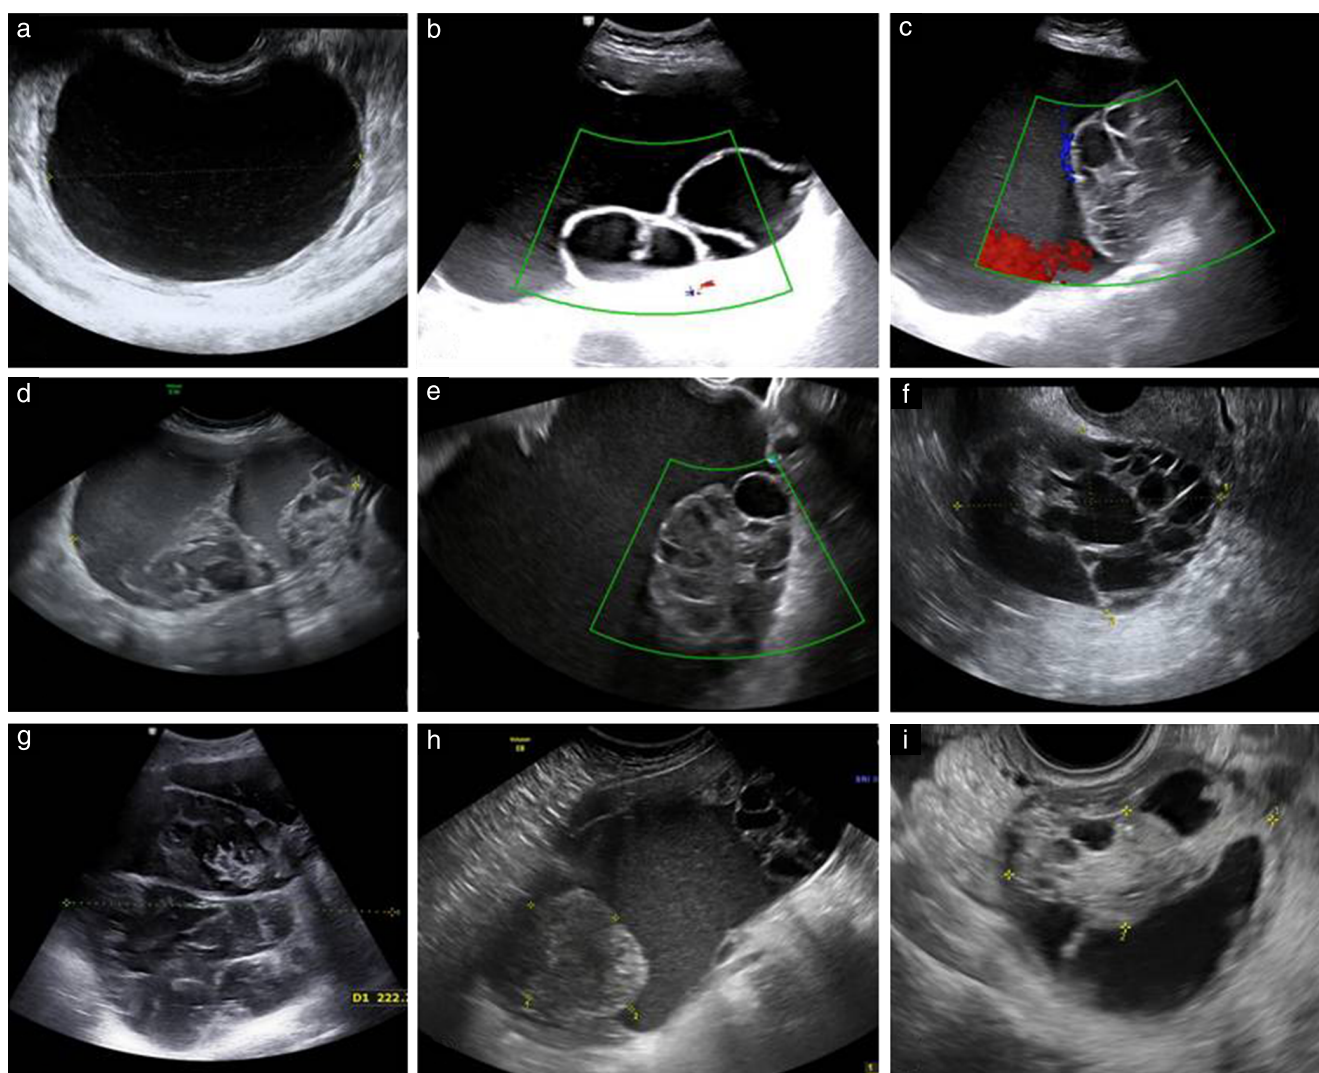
Ultrasound images of gastrointestinal-type borderline ovarian tumors, presenting as unilocular (a), multilocular (b–g) or multilocular-solid (h,i) cysts, the majority being multilocular cysts with > 10 locules (c–g), rather than 2–10 locules (b). Honeycomb nodule can often be visualized (c–e). Lesions in (c–e) were diagnosed correctly by ultrasound examiner as borderline, masses in (a,b) were misdiagnosed as benign and masses in (f–i) were misdiagnosed as invasive.
